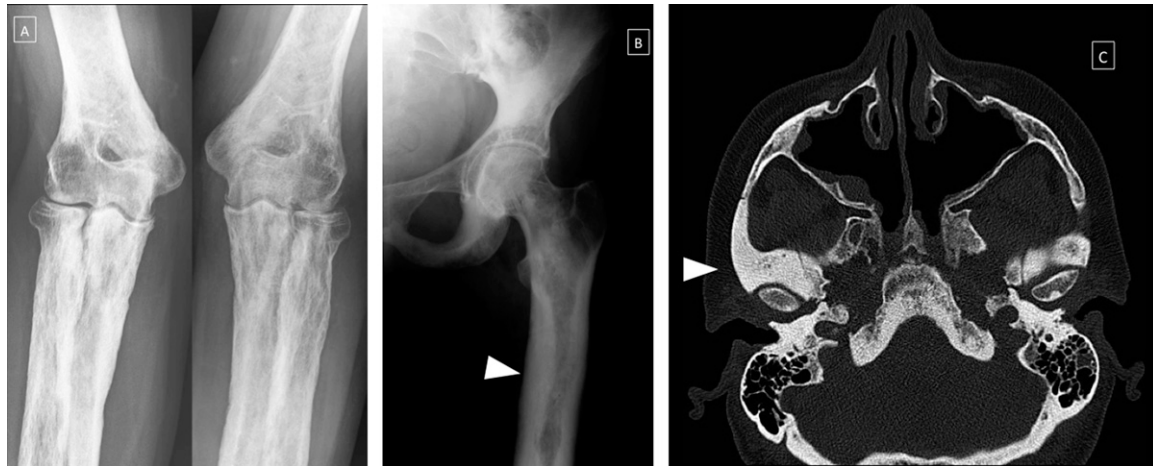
Progressive diaphyseal dysplasia. A 50-year-old female. (a) Frontal radiograph of both elbows showing bilateral symmetric hyperostosis along the periosteal and endosteal surfaces of the diaphysis of the long bones. (b) Frontal radiograph of the left hip showing sclerosis of the left iliac wing, ischium and diaphysis of the femur, with narrowing of the medullary canal and increase in the diaphyseal diameter (arrowhead). (c) CT scan of the skull base. Note the sclerosis of the skull base and around the temporomandibular joints (arrowhead). Note that maxillary sinus surgery has been performed.
